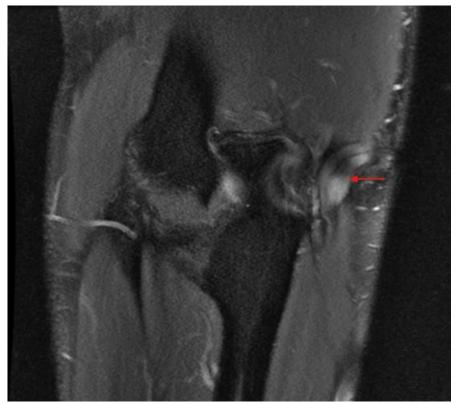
Coronal PD MRI view demonstrate high signal intensity within the nerve
